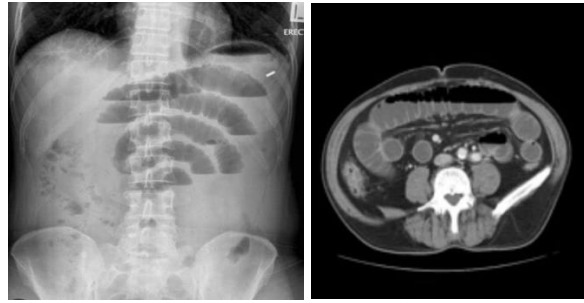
CT scan abdomen with IV contrast showing dilated small bowel loops
